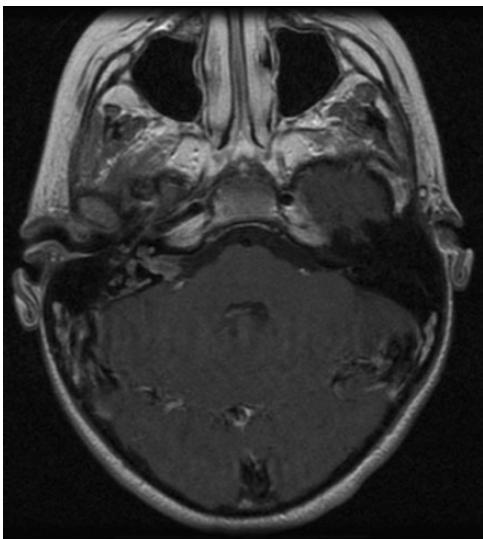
Axial T₁-weighted postgadolinium MRI showing tumor in the endolymphatic sac area with spread into the vestibule, cochlea, and internal auditory canal. MRI indicates magnetic resonance imaging.
